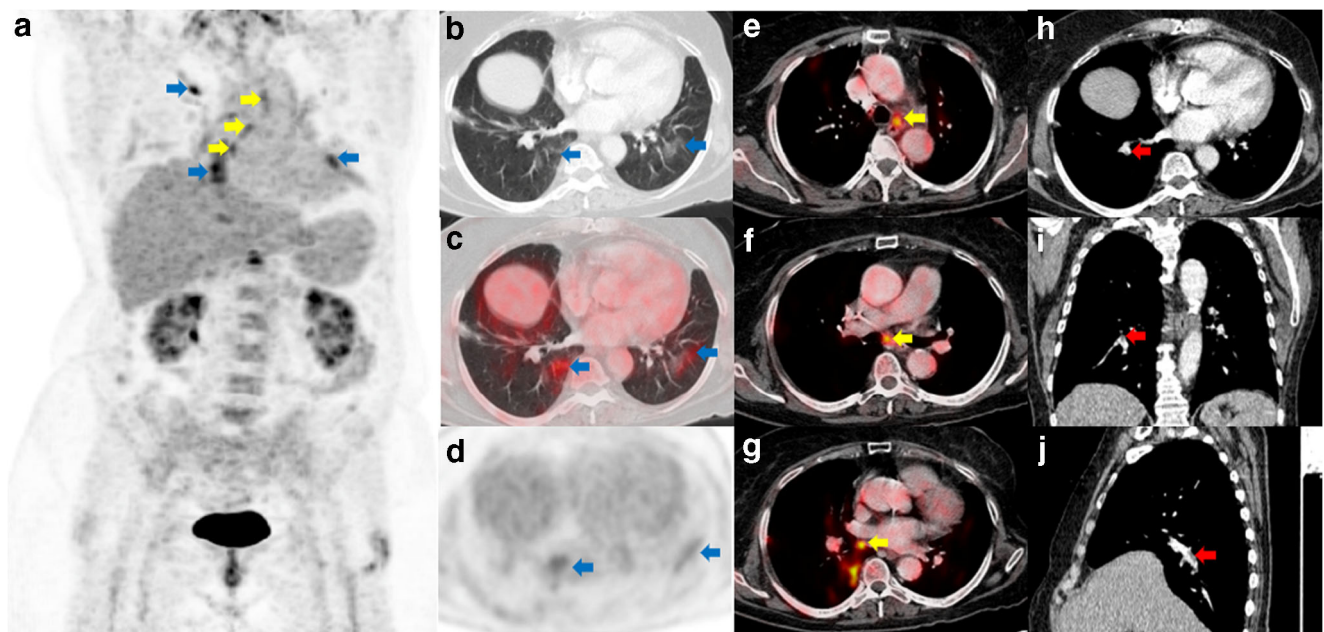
A 70-year-old woman with head and neck cancer treated with surgery, chemotherapy and radiotherapy, MIP follow-up PET-CT (a) showing FDG uptake in lung infiltrates (blue arrows) and thoracic lymph nodes (yellow arrows). We can also observe intense FDG uptake in both subclavian arteries and mild uptake in thoracic aorta (green arrows). CT (b), fusion (c), and PET (d) axial views demonstrating bilateral ground-glass opacities in lungs with FDG uptake (blue arrows). (e, f, g) PET-CT
